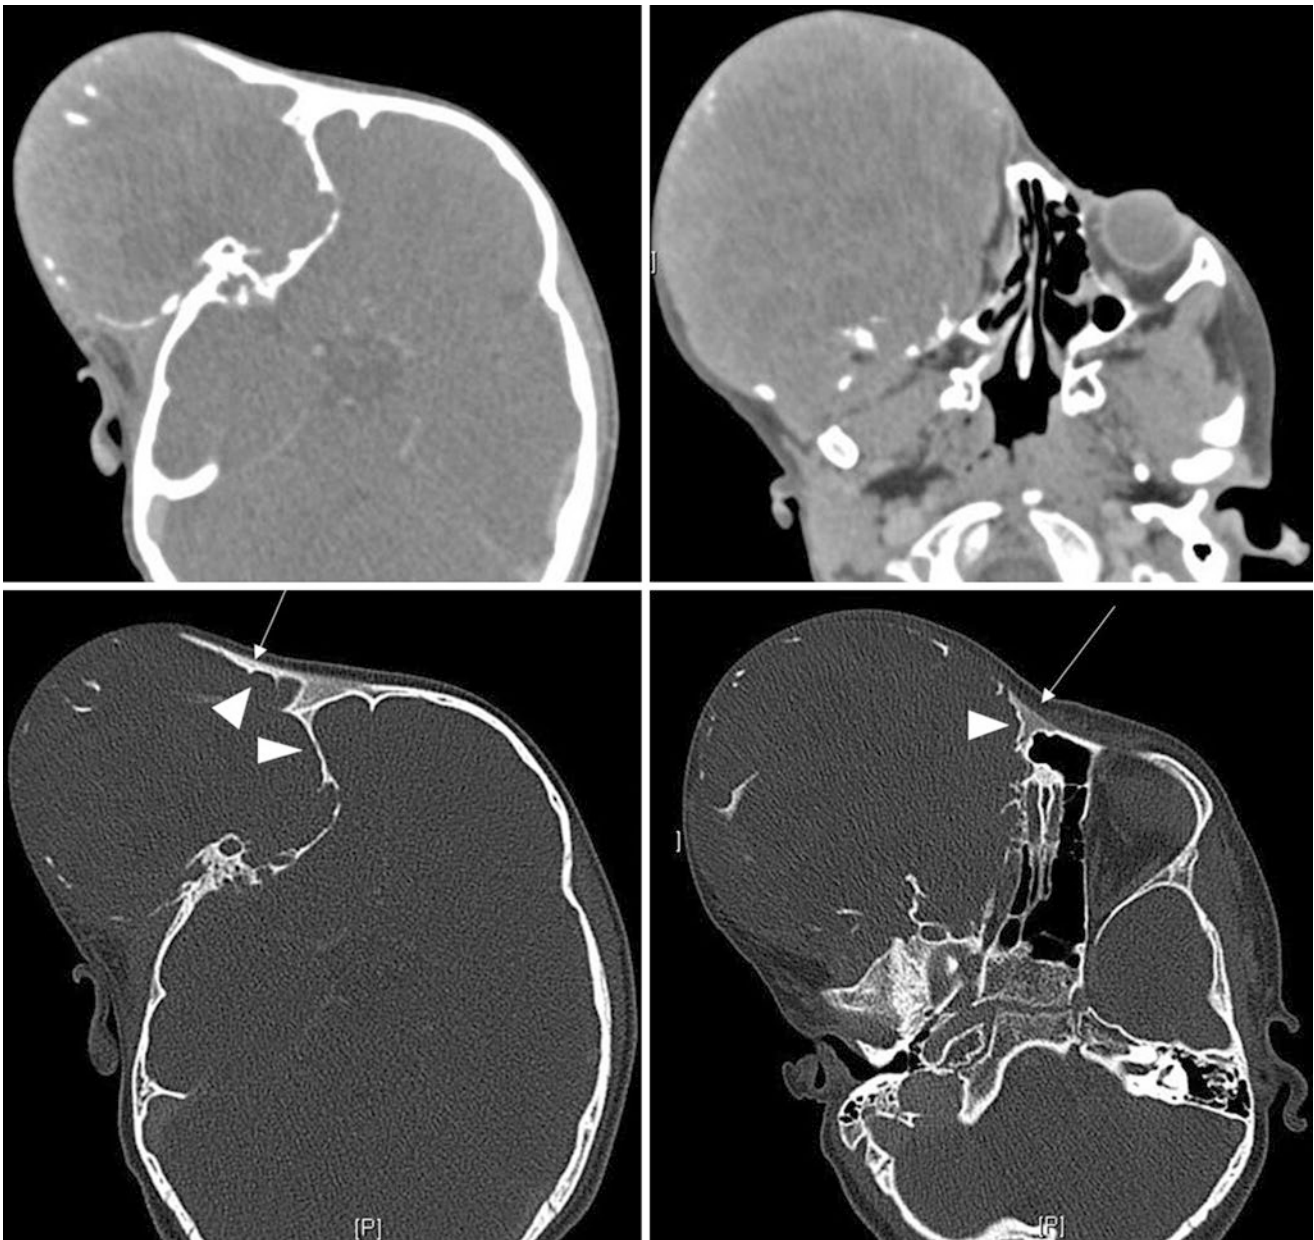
Contrast-enhanced CT with bone and soft tissue windows showing a large, lucent, expansile mass centred on the right fronto-orbital region. There is evidence of bony remodeling with new bone
